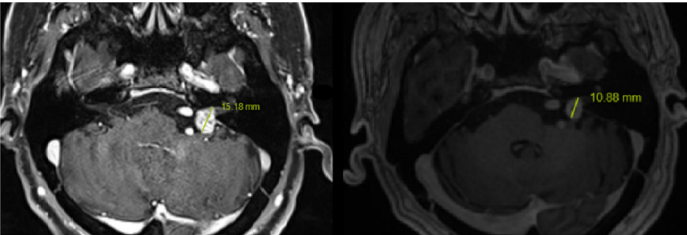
Partial tumor response in magnetic resonance imaging taken before treatment and during the 24-month follow-up period of a patient who underwent SRT at 12 Gy/1 fraction
